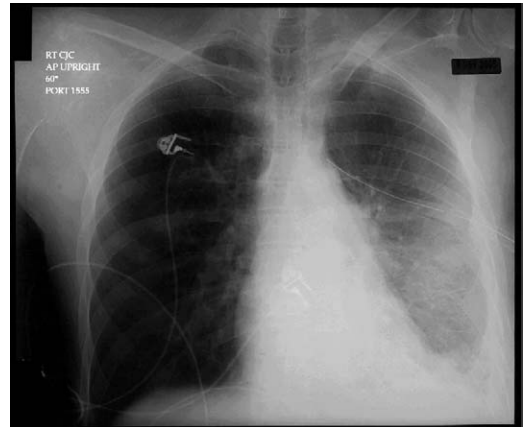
Chest radiograph obtained immediately after chest tube placement confirms appropriate tube position and left lung reexpansion.
